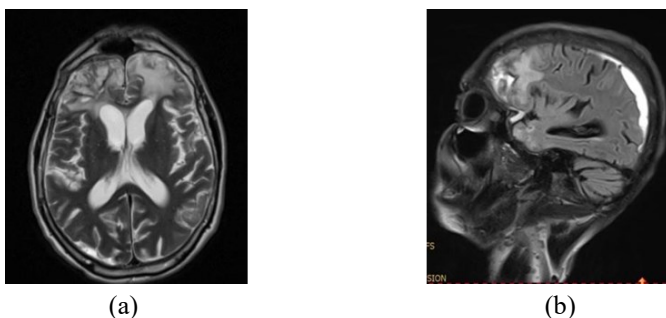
MRI scan 2 months post-injury (a) sagittal T2w (b) transversal T2w
